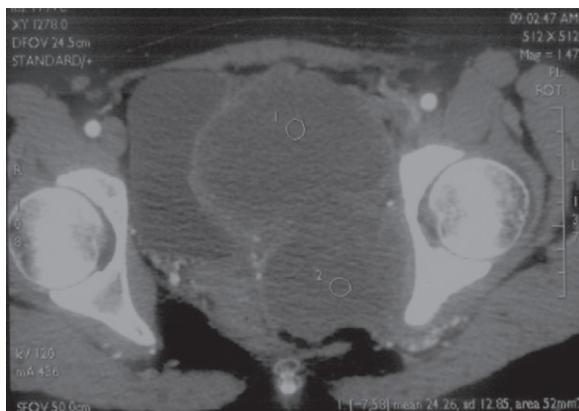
CT, a big tumor in the pelvis minor, inhomogeneous contrast enhancement, with areas of necrosis.
